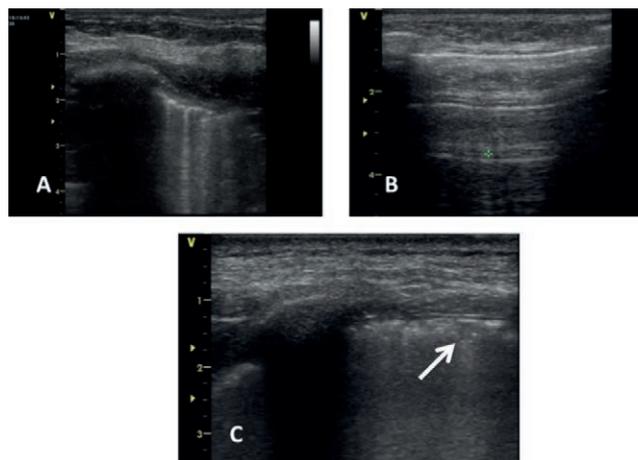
Main chest ultrasound lung findings. A) B-lines. B) Am lines. C) Large consolidation.
